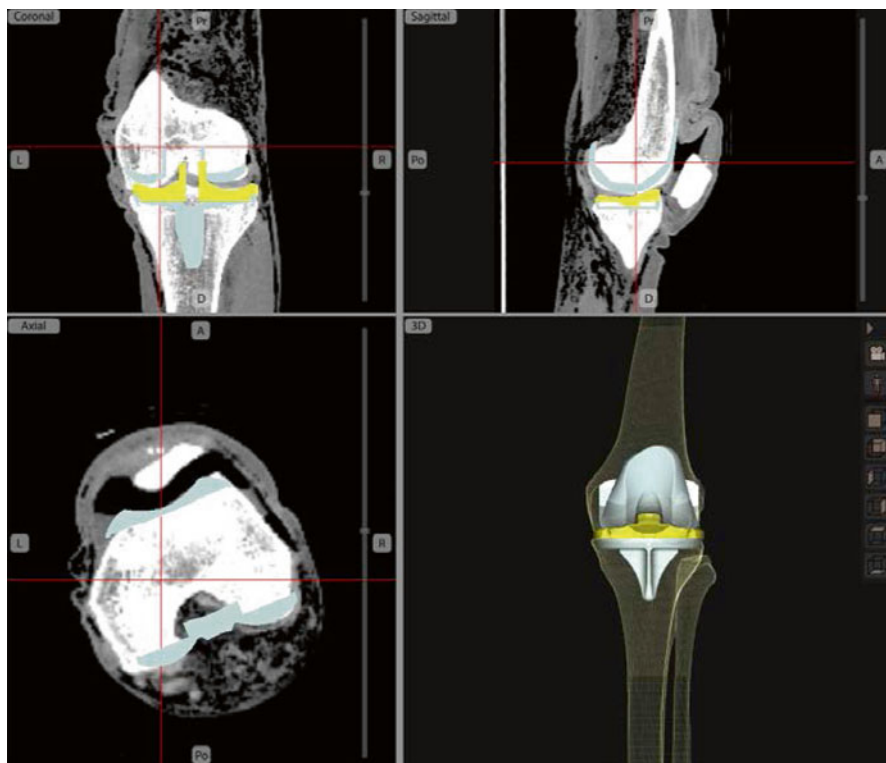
Planning based on CT (SOS screen capture)
